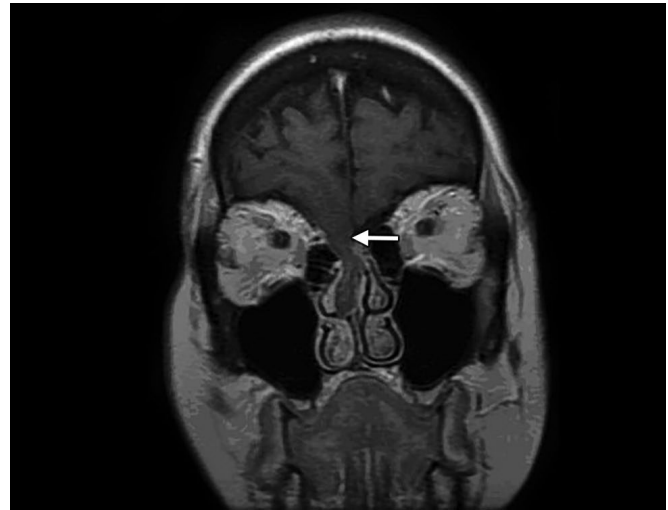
T1-weighted coronal MRI of a patient with benign intracranial hypertension. A broad-based right cribriform defect is noted (arrow).
